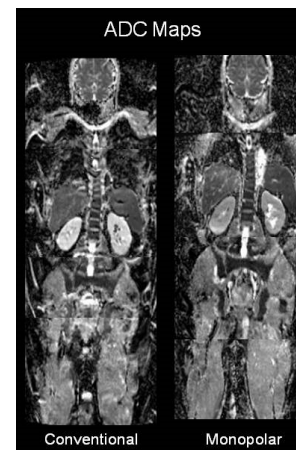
Example of WB-ADC maps constructed monopolar and conventional bipolar DWI.
